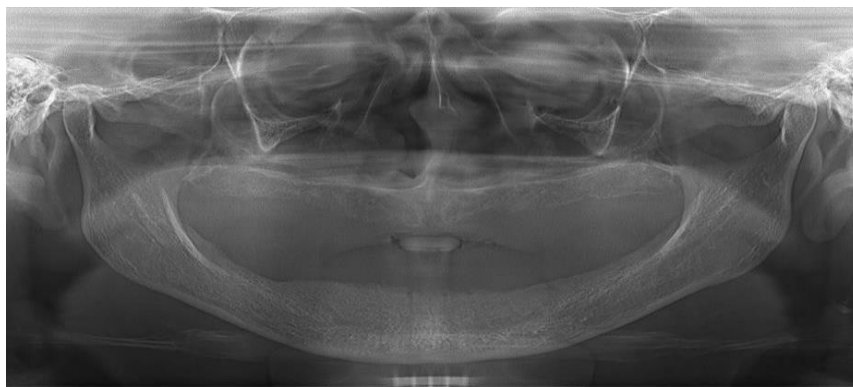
Panoramic radiography examination
